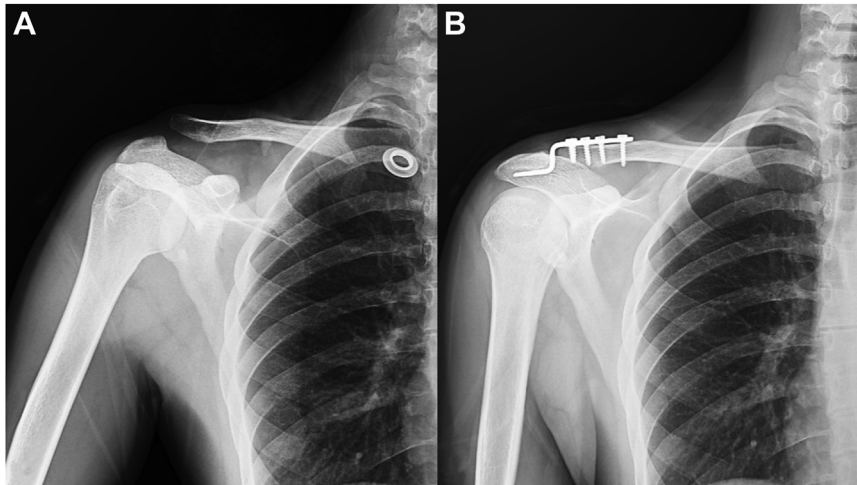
(A) Rockwood type V ACJ dislocation seen on the shoulder AP radiograph of the patient, who applied to a different hospital 6 years ago. (B) Immediate postoperative radiograph of the patient, who had undergone HP fixation. ACJ, acromioclavicular joint; AP, anteroposterior.
